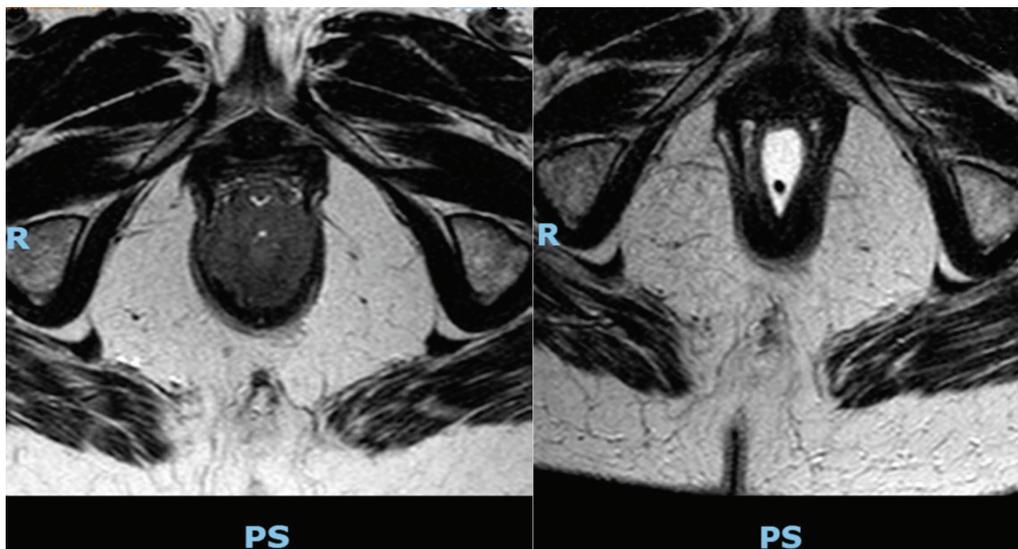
MRI staging of rectal adenocarcinoma pre-neoadjuvant therapy (left) and post-neoadjuvant therapy (right)
